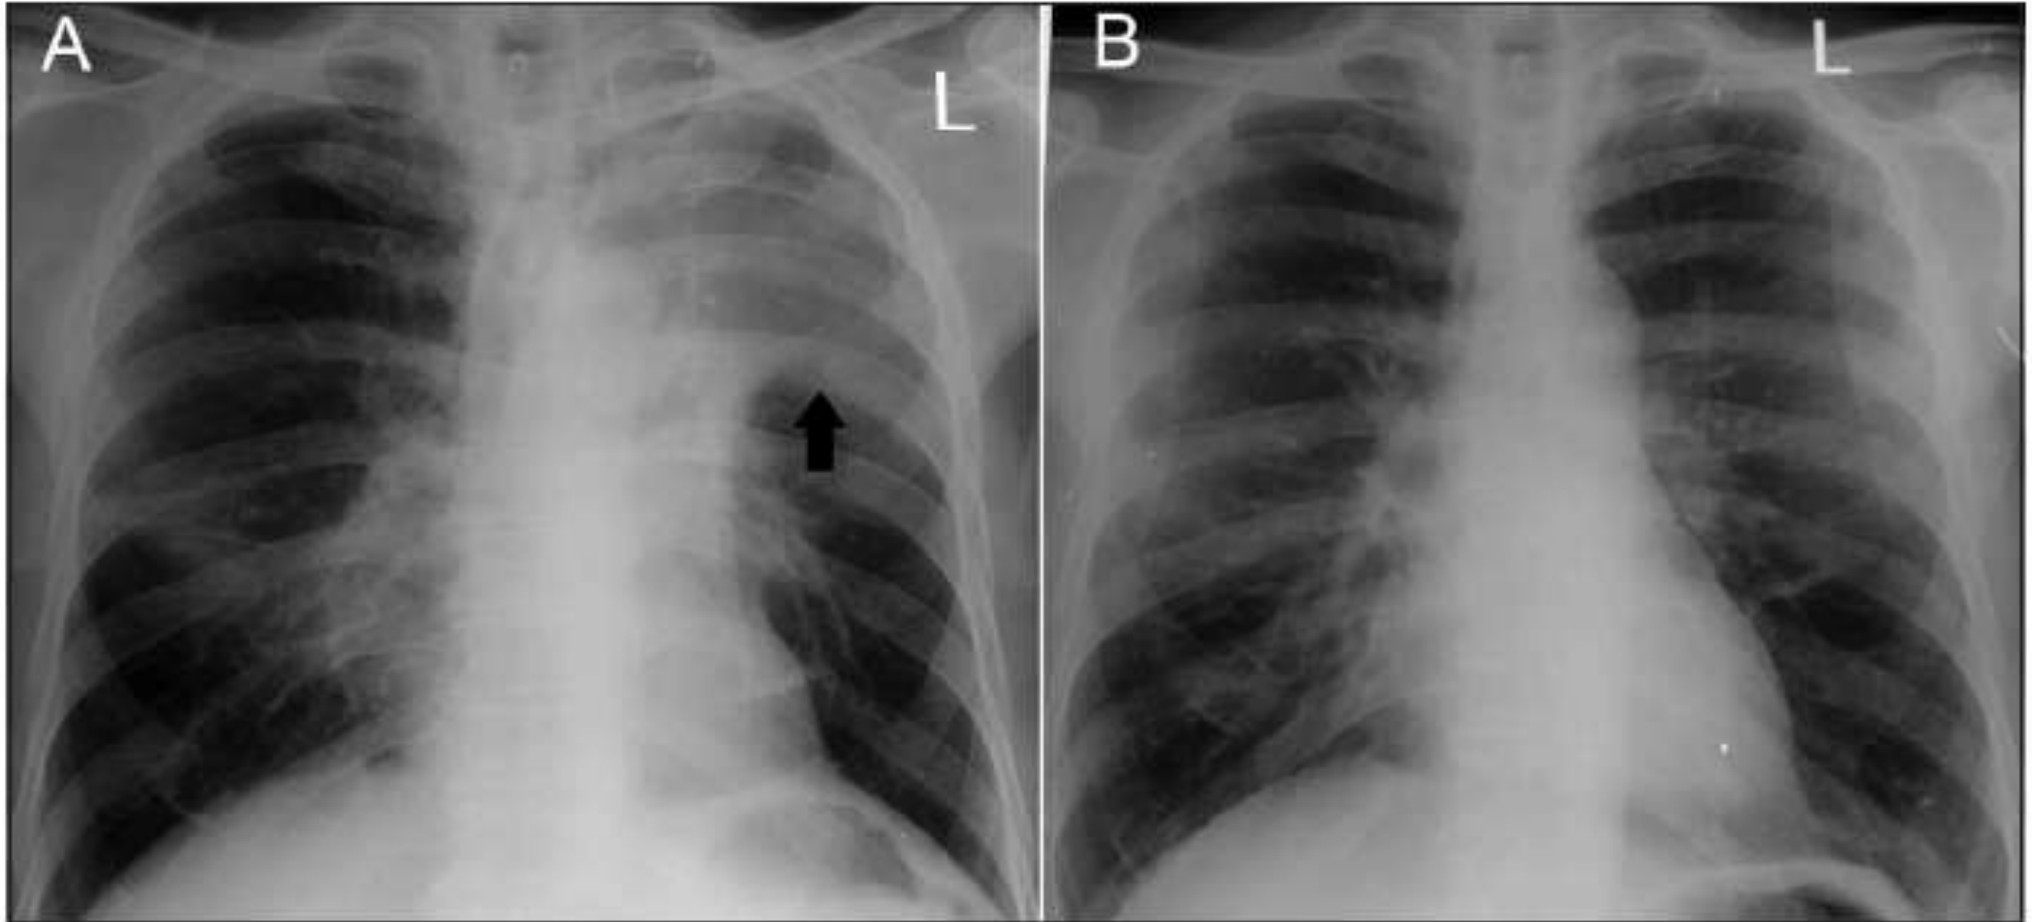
Chest radiograph shows mucoid impaction with the classic finger-in-glove pattern (arrow)
